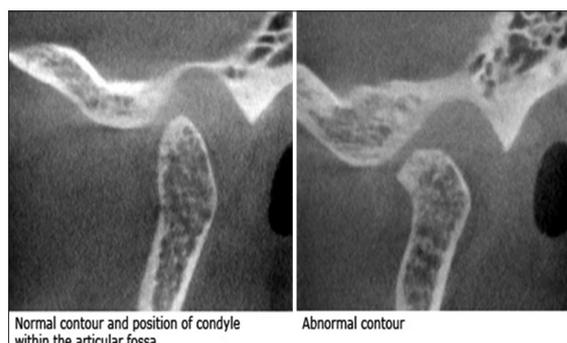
Cone-beam computerized tomography of normal and abnormal temporomandibular joint
